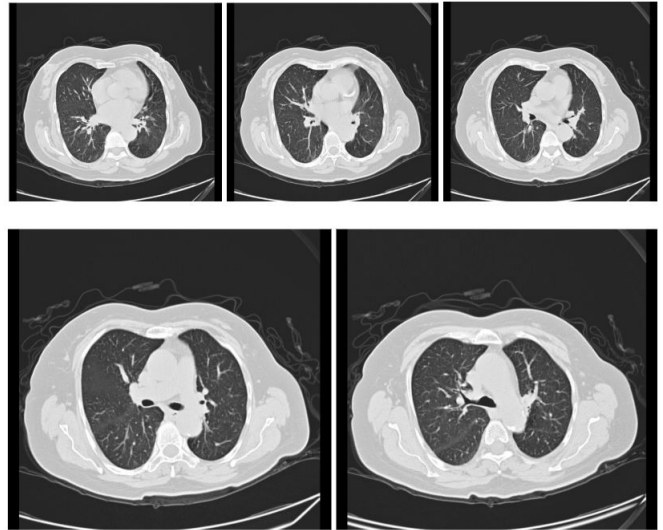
Virus pneumonia image showing bilateral ground glass appearance in the lungs on chest CT taken in hospitalization of the patient
